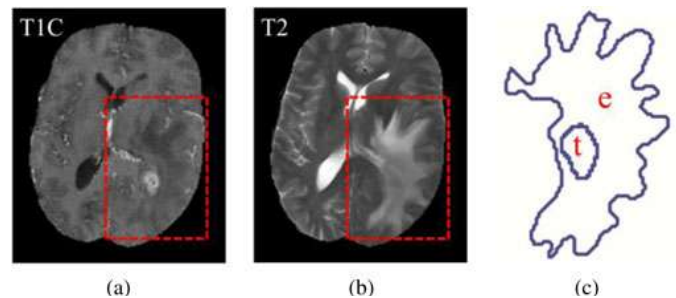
Different modalities reveal different parts in the tumor area. The edge of the tumor area is visually vague. In addition, the brain structure is deformed because of the occurrence of edema. (a) TIC-weighted brain tumor MRI image. (b) T2-weighted brain tumor MRI image. (c) Contour of the actual brain tumor. “t” represents the combination of contrast-enhancing and necrotic parts, and “e” represents the edema part.
